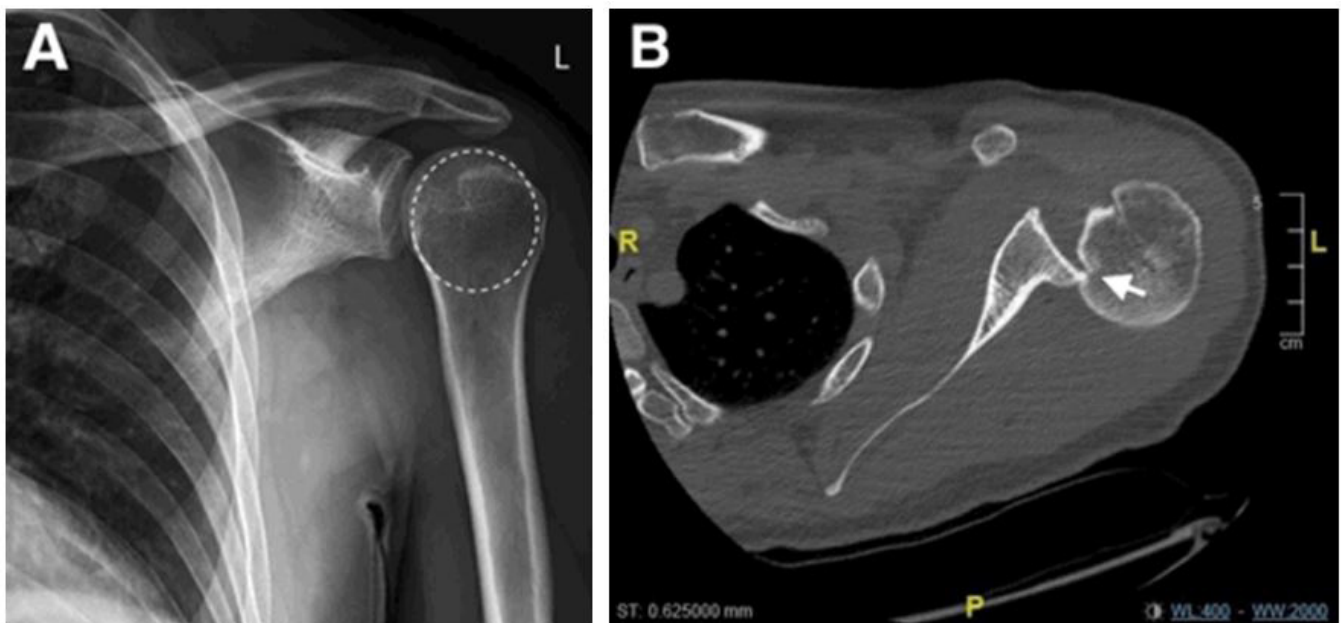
A. X-ray left shoulder incidence face objectifying an internal rotation of the humeral head (= sign of the bulb).
